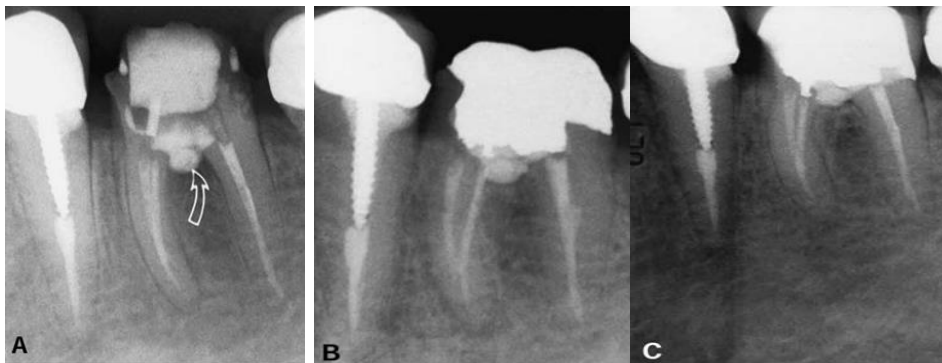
Furcation repair using mineral trioxide aggregate (MTA). A, Radiograph shows repair of perforation using MTA (arrow). B, Six months after repair. C, eighteen months after repair, intact furcation support is
